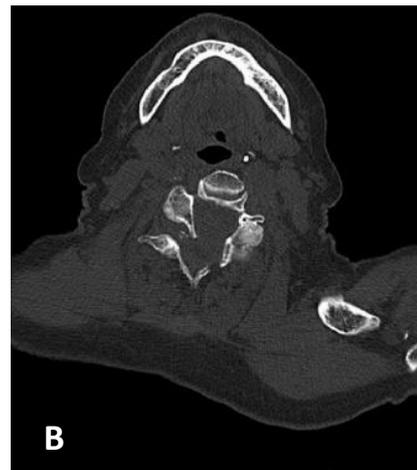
CT imaging for Case 1. B) Axial CT demonstrating overlapping posterior elements due to an associated laminar fracture, resulting in spinal canal enlargement at the site of potential cord compression.
